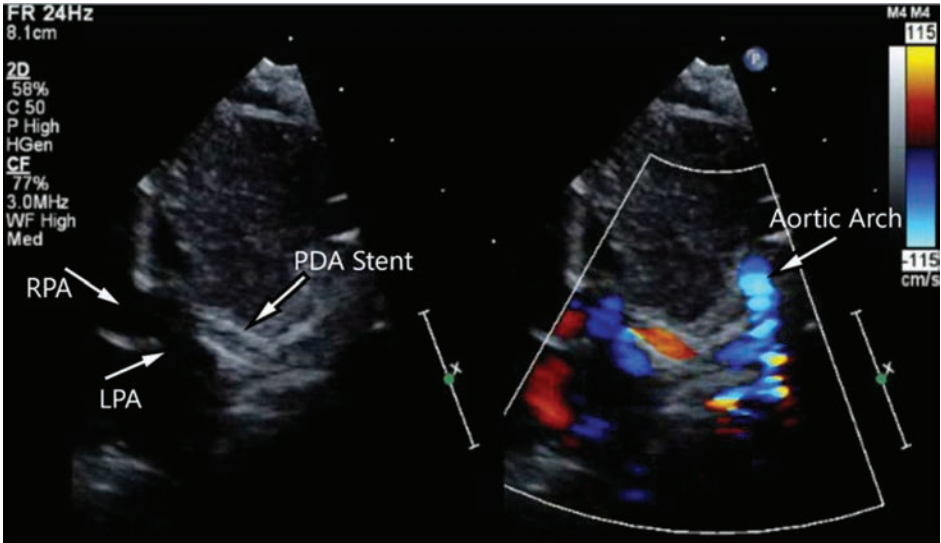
Echocardiographic image with color-compare showing a patent PDA stent.
